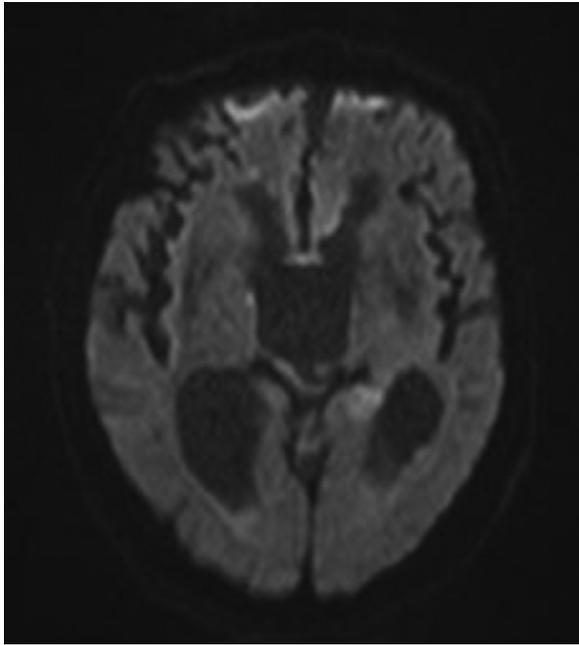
MRI diffusion-weighted magnetic resonance imaging (DWI) 1 day after the treatment showing no ischemic lesion in the left occipital lobe.
